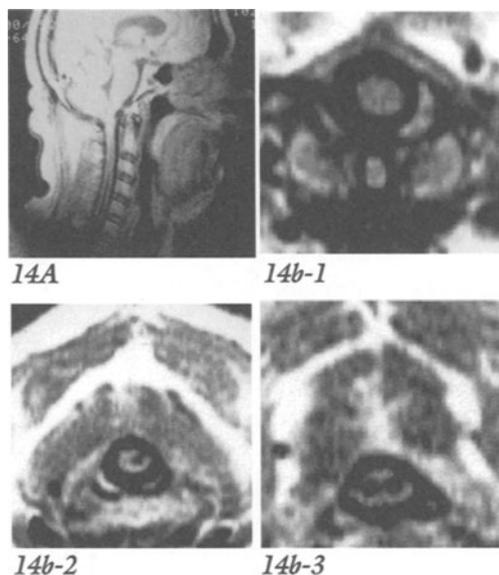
Syringomyelia. Case History #9-6. (CASE ON CD ROM). MRI Scan. This 60 year old male had clinical findings of syringomyelia and syringobulbia. A) Midline Sagittal Section demonstrating a central cavity beginning at the cervical two segment and extending well into the upper thoracic segments. B) Transverse Sections demonstrating the irregular nature of the central cavity. 1) Cervical 1-level, no definite cavity. 2) Cervical 2 Level-cavity is predominately right sided extending into right posterior column, 3) Cervical 4 Level-bilateral cavities.
